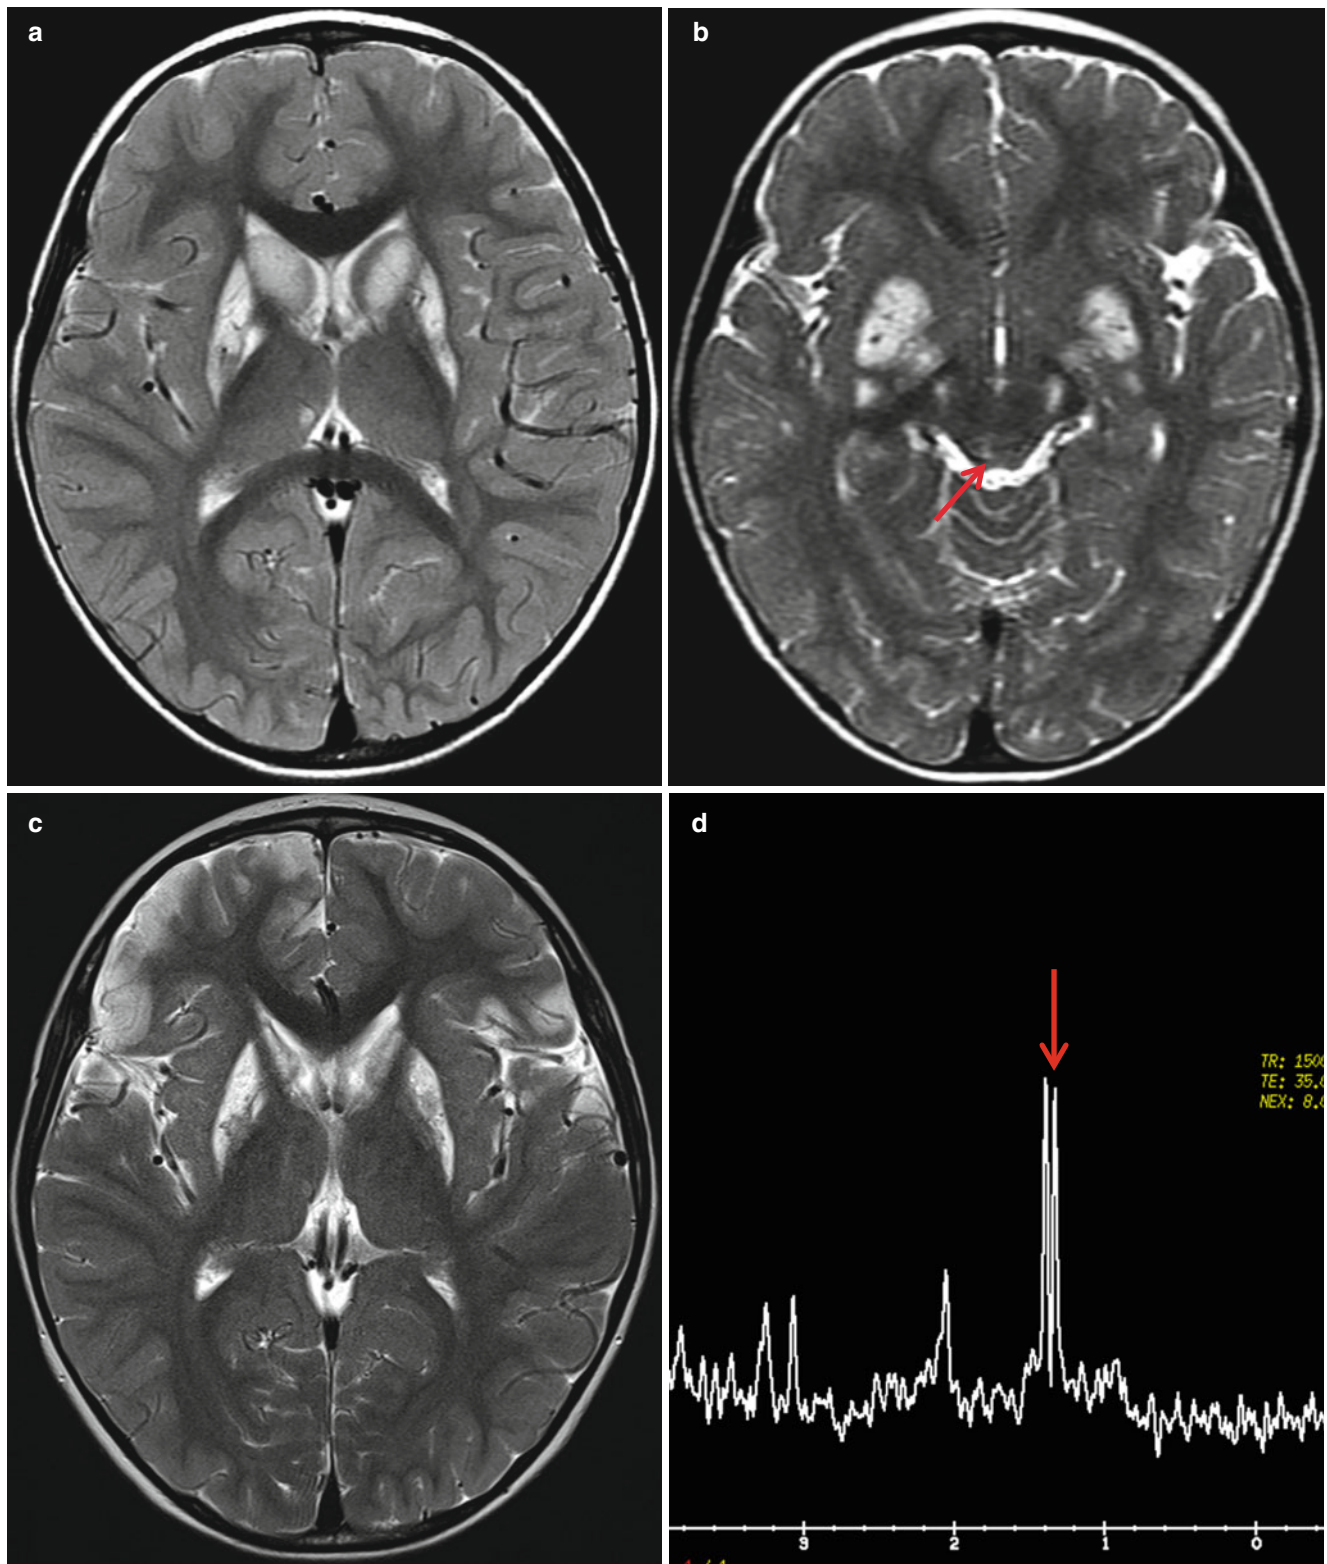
Leigh disease in a 2-year-old boy with gait disturbance. (a, b) T2-weighted images show high-signal intensity of the basal ganglia, midbrain, and periaqueductal gray matter (*arrow*). (c) Follow-up image
